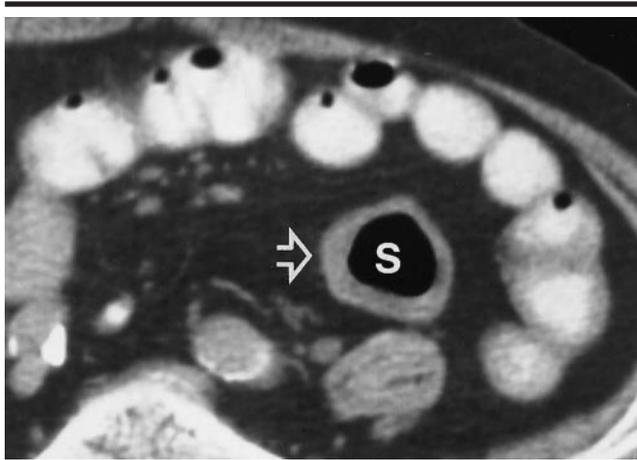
Ischemic colitis of left colon in a 67-year-old man with left lower quadrant pain and an elevated WBC count, who was suspected of having diverticulitis. Contrast-enhanced CT scan reveals segmental colitis involving the descending and sigmoid colon (arrow, S). The thickened wall of the sigmoid colon has a dry appearance with a sharply defined, homogeneously enhancing wall, without pericolic streakiness or fluid collections. Sigmoidoscopy showed hemorrhagic mucosa with patchy areas of mucosal necrosis. Surgery 18 hours later revealed full-thickness necrosis of the left colon, which necessitated resection. The rectum was normal.
